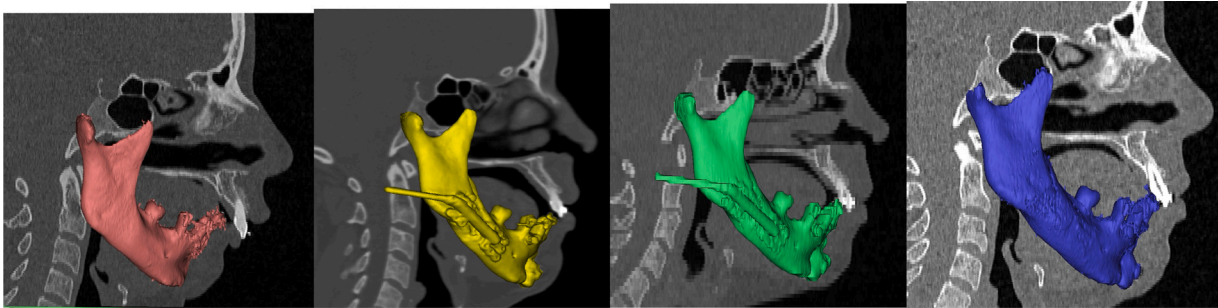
CT 3D reconstruction in sagittal section showing comparative pre-surgical jaw (9.1) and post-surgical jaw at 3 (9.2), 6 (9.3) and 9 months (9.4).
